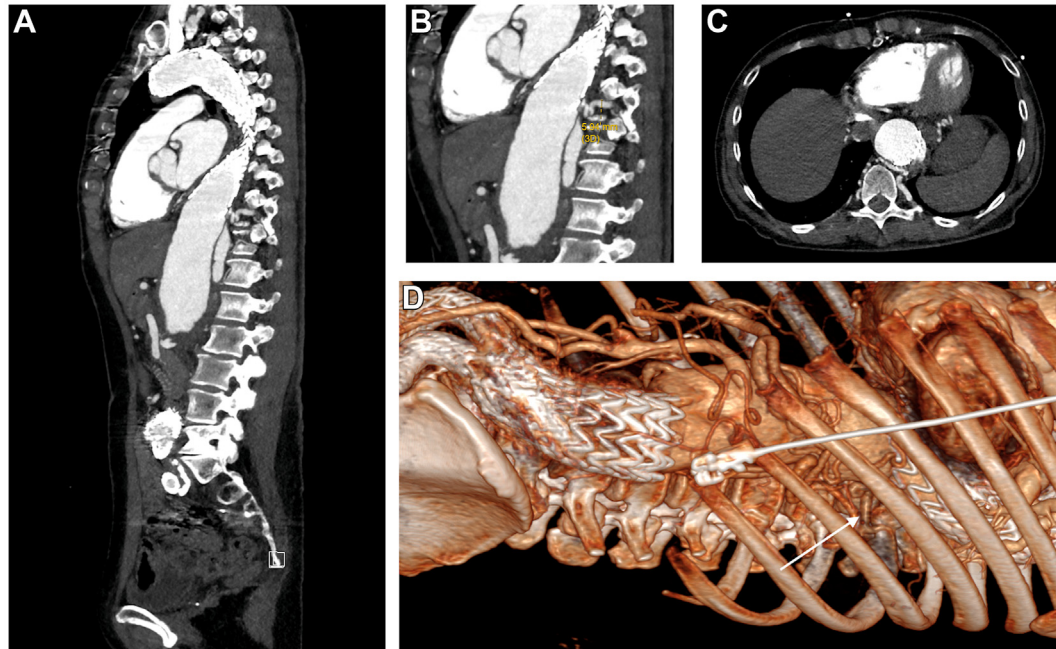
Preoperative computed tomography angiography (CTA) images demonstrating a prominent left T10 segmental artery: sagittal view (A), zoomed sagittal view demonstrating an artery diameter of 5.94 mm (B), axial view (C), and three-dimensional reconstructed lateral view demonstrating the artery (D; white arrow).
